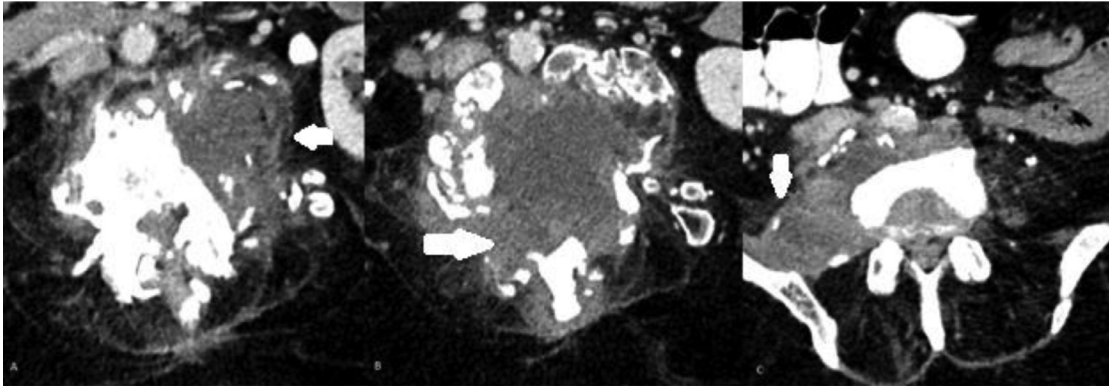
The preoperative CT scan (A) showed inflammatory bone damage below the spinal fusion and extend of infection in the paravertebral tissue (B) with abscess formation in the right psoas muscle (C) (white arrows).
